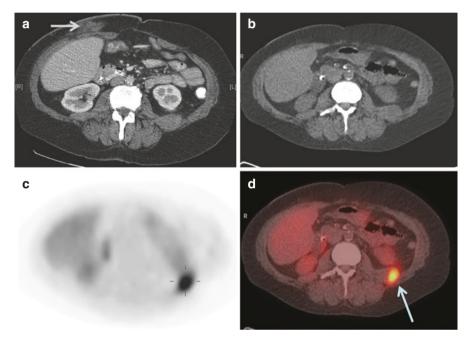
Role of FDG PET-CT in patients with unexplained rising CEA levels. 55-year-old female with previous sigmoid cancer and rising CEA levels. Contrast enhanced CT (a) was reported as being unremarkable. Stranding noted at site of reversal of ileostomy (arrow). FDG PET-CT with unenhanced CT (b), attenuation corrected (c) and fused images (d) demonstrate an intensely FDG avid focus of uptake in the left quadratus lumborum muscle (arrow in d) confirmed to represent an intramuscular metastasis. On retrospect on CT asymmetry in the muscle bulk due to a soft tissue lesion can be seen. FDG PET CT is a useful problem solving tool to identify potentially occult causes for rising CEA
